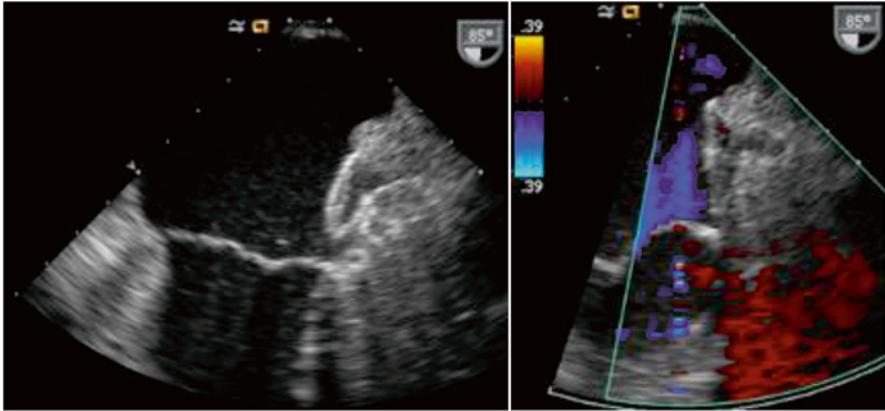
The ACP device deployed in the LAA. The lobe (most distal part of the device) should have 2/3 past the LCx. The disc is then deployed once the position is stable, and colour Doppler is used to assess sealing of the LAA at the ostium. Images courtesy of Dr J Saw, Vancouver General Hospital
